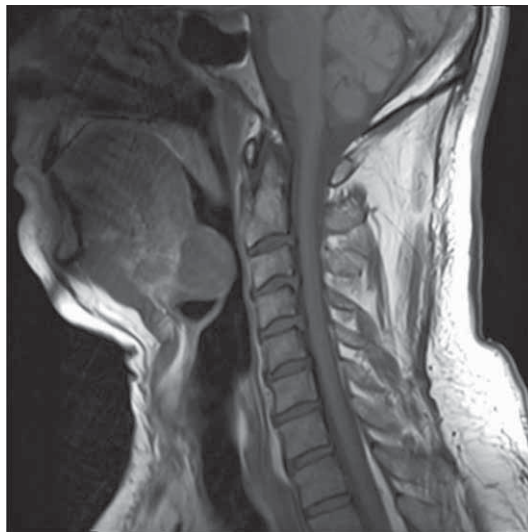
On the left side, in region II a necrotic lymph node is visible. This sagittal T1 WI MRI scan shows sharply delineated lesion at the base of tongue, at the expected location of foramen cecum. The signal of this lesion is isointensive with surrounding musculature.
